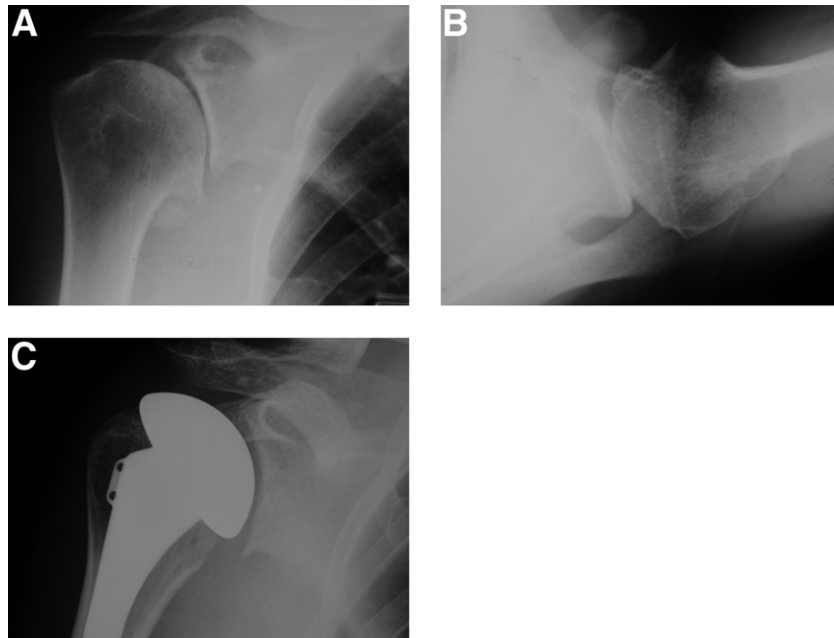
A, A true anteroposterior (AP) view of a right shoulder with advanced shoulder degenerative joint disease. There is loss of joint space and marginal osteophytes. B, An axillary view of the same shoulder reveals bone-on-bone contact and very mild posterior subluxation of the humeral head on the degenerative glenoid. C, A true AP radiograph of a right shoulder 1 year after total shoulder arthroplasty with a lateral meniscus allograft. The joint space has been maintained and is symmetric.
